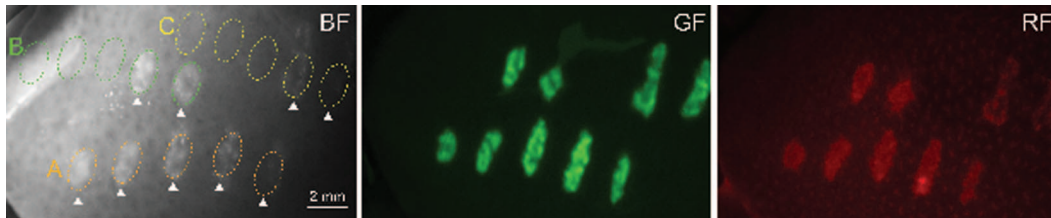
Macroscopic images of the region showing various parameters of release (left: bright field, center: GFP filter, right: DSred filter). In region A, the five release points were produced with 1, 3, 10, 20, 100 pulses at 4.4 MPa. The two other series B and C were produced with 1000 pulses at 1.2, 2.0, 2.6, 3.5, and 4.4 MPa. Focusing pulses at 1.2, 2.0, and 2.6 MPa did not produce fluorescent regions, nor ultrasound contrast.
